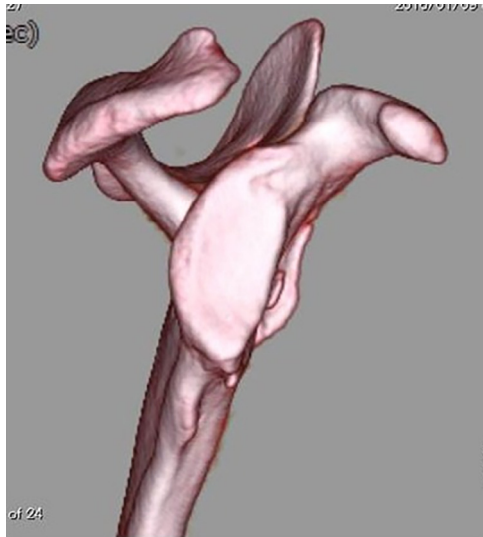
Preoperative 3-dimensional reconstructed computed tomography in face view of the right glenoid shows glenoid defect (bone loss, 36.9%).
